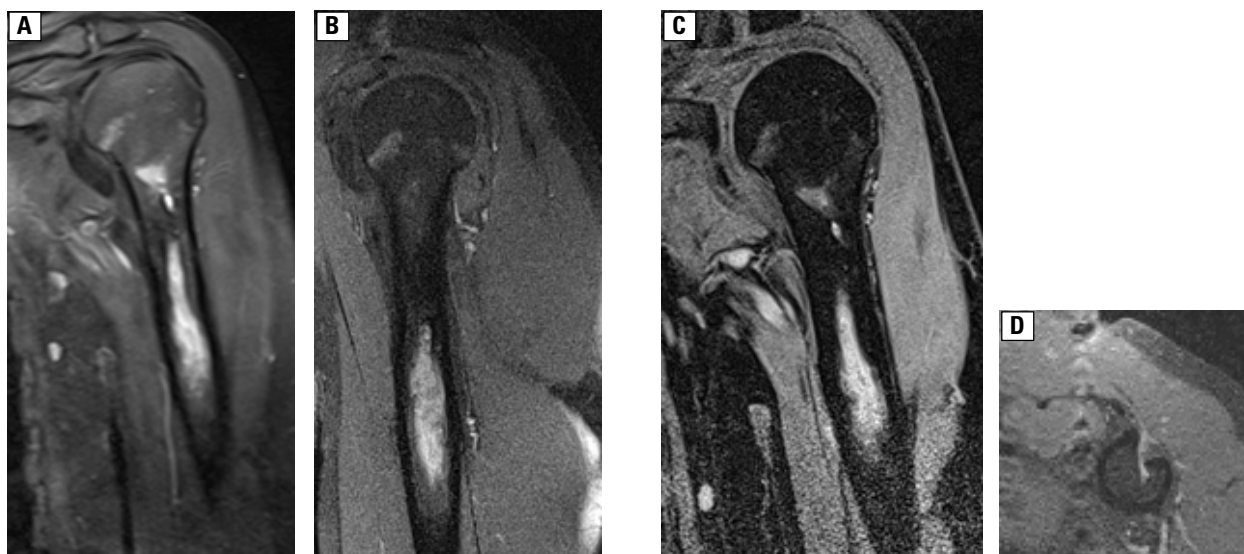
Follow-up MRI examination of the brachium. A, B — coronal and sagittal PD weighted images with fat saturation; C, D — axial and coronal T1-weighted CE images with fat saturation
